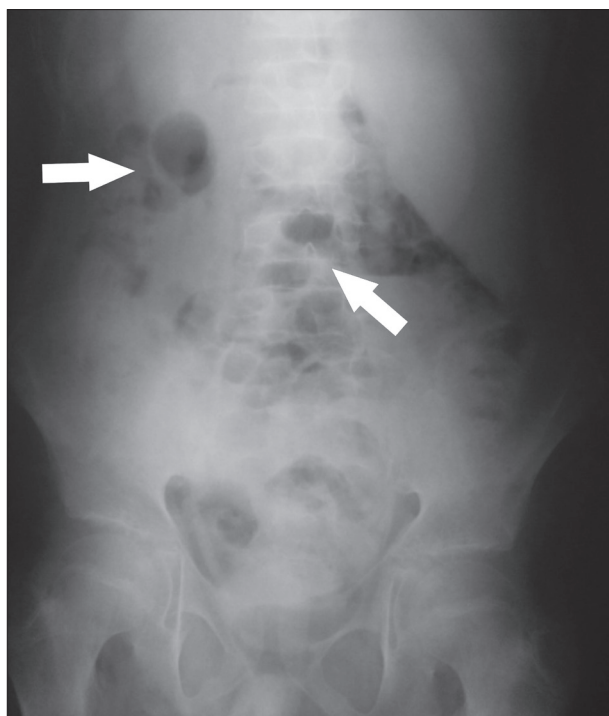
Chest X-ray image showing air in the peritoneal cavity (arrows)
